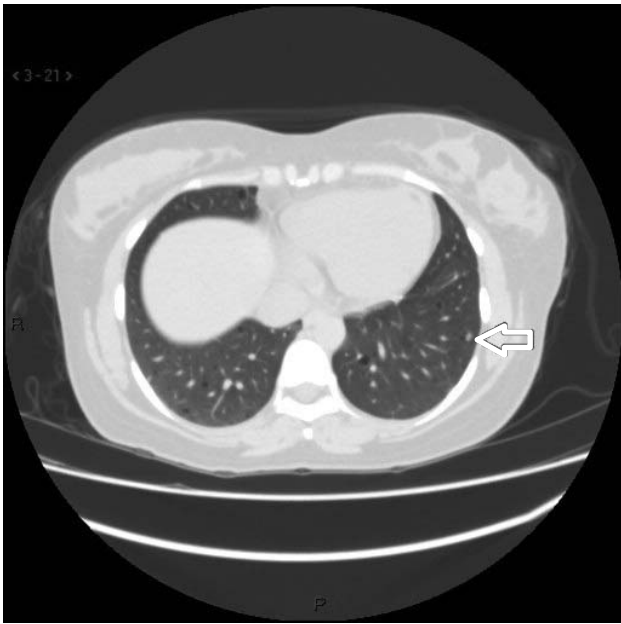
Multifocal micronodular pneumocyte hyperplasia (MMPH) on lung window of CT chest
